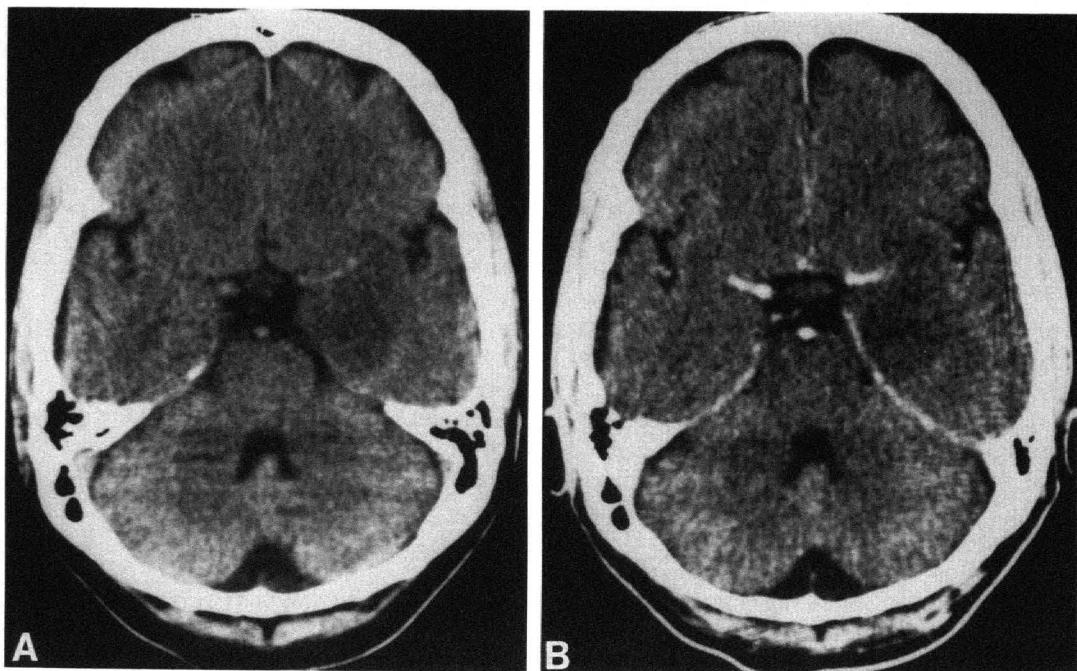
Axial CT images of low-grade astrocytoma. A: Noncontrast scan demonstrating low-density area in left medial temporal lobe with minimal mass effect. B: Enhanced CT image showing no enhancement of the tumor.
